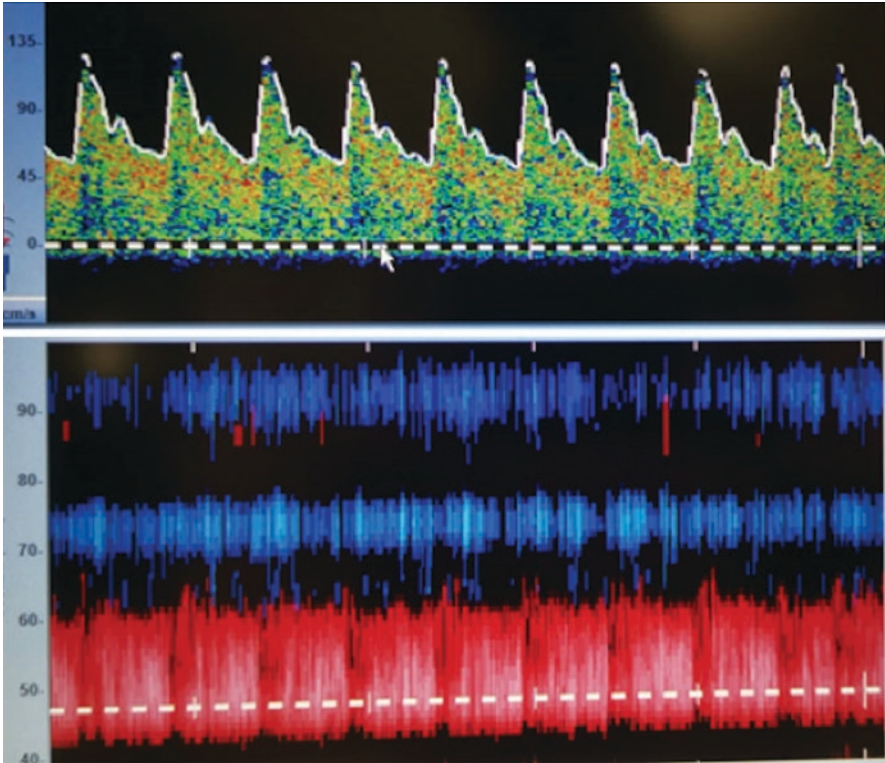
The M mode or "Power Mode". The two panels that appear on the computer screen when using this mode are shown. The insonation is through transtemporal acoustic window. In the upper panel you can see the Doppler spectrum, where equipment has delineated the spectral Doppler envelope. In this case it is a laminar blood flow. The lower panel shows the M-mode, which displays all the flows in the path of the ultrasonic beam, their depths in relation to the surface of the transducer and their directions (towards the transducer in red and away from it in blue). The scale on the left shows at what depth, in mm, these flows are seen. Between 40 and 60 mm there is a flow that approaches the transducer, which corresponds to the middle cerebral artery (MCA). In this red band there is a dotted line, which shows the depth at which the artery is being observed, in this case about 48 mm; at this depth corresponds the spectrum seen in the upper panel. Any point can be chosen, so that the volume of the sample will inspect and show on the upper display the spectrum and the corresponding envelope with its PSV, MFV, EDV and PI. Between 70 and 75 mm a flow is seen that moves away, corresponding to the anterior cerebral artery (ACA). The carotid bifurcation is not clearly seen in this image, but at about 62 mm a blue band can be seen at times, so it can be thought that this is the bifurcation and that by slightly angulating the transducer it could be clearly found
